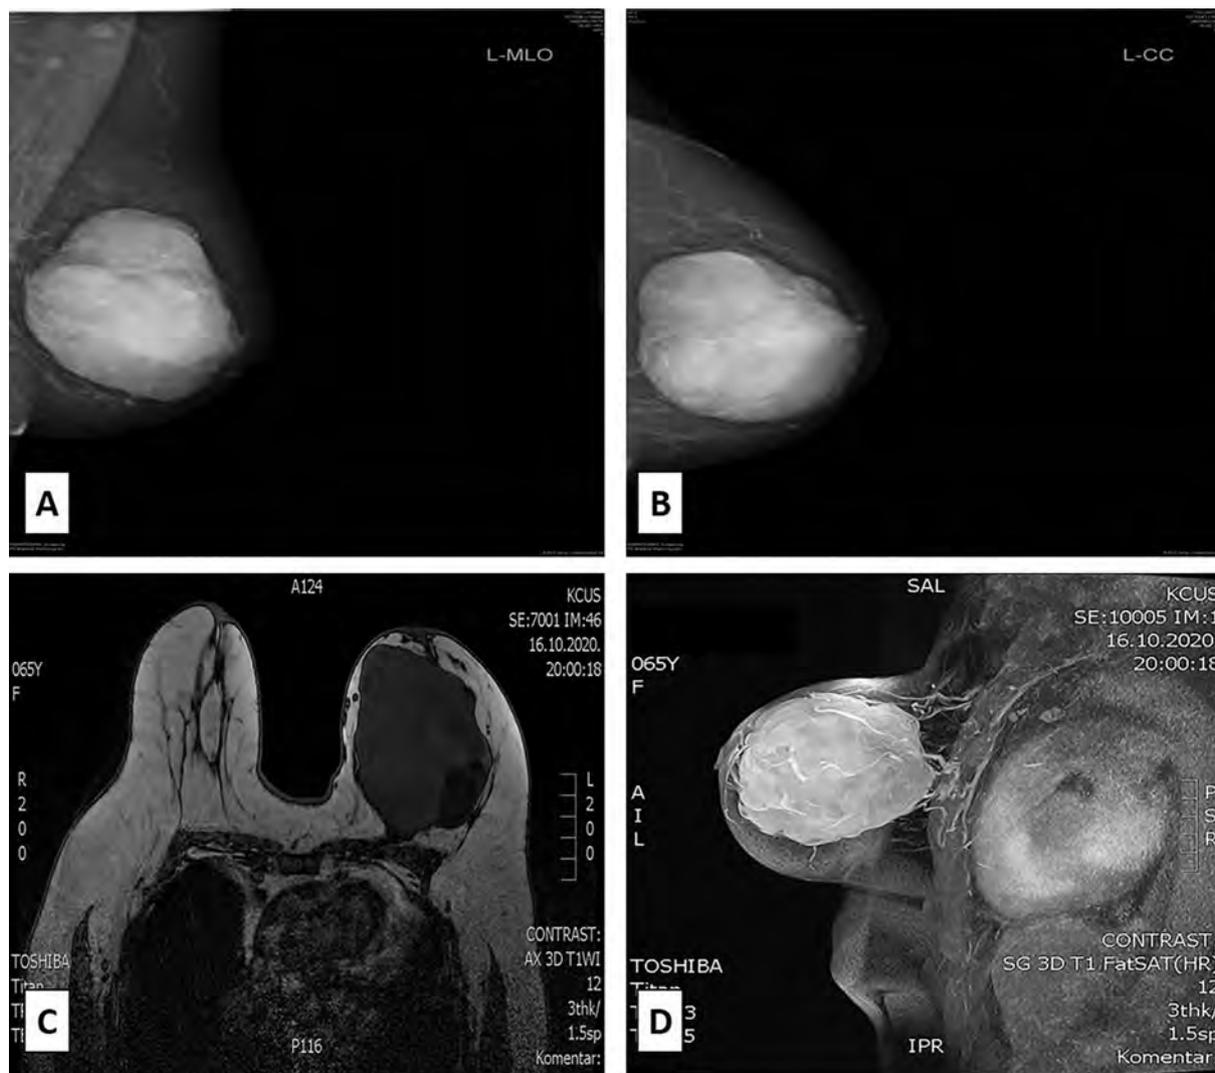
Mammograms on the standard view (MLO and CC) revealed a round, dense mass partially surrounded by a clear halo, without any calcifications (A-B); Axial T1W1 MRI scans revealed a hypointense mass with some hyperintense foci of hemorrhage (C); Sagittal post-gadolinium subtraction image also showed intense enhancement (D).
